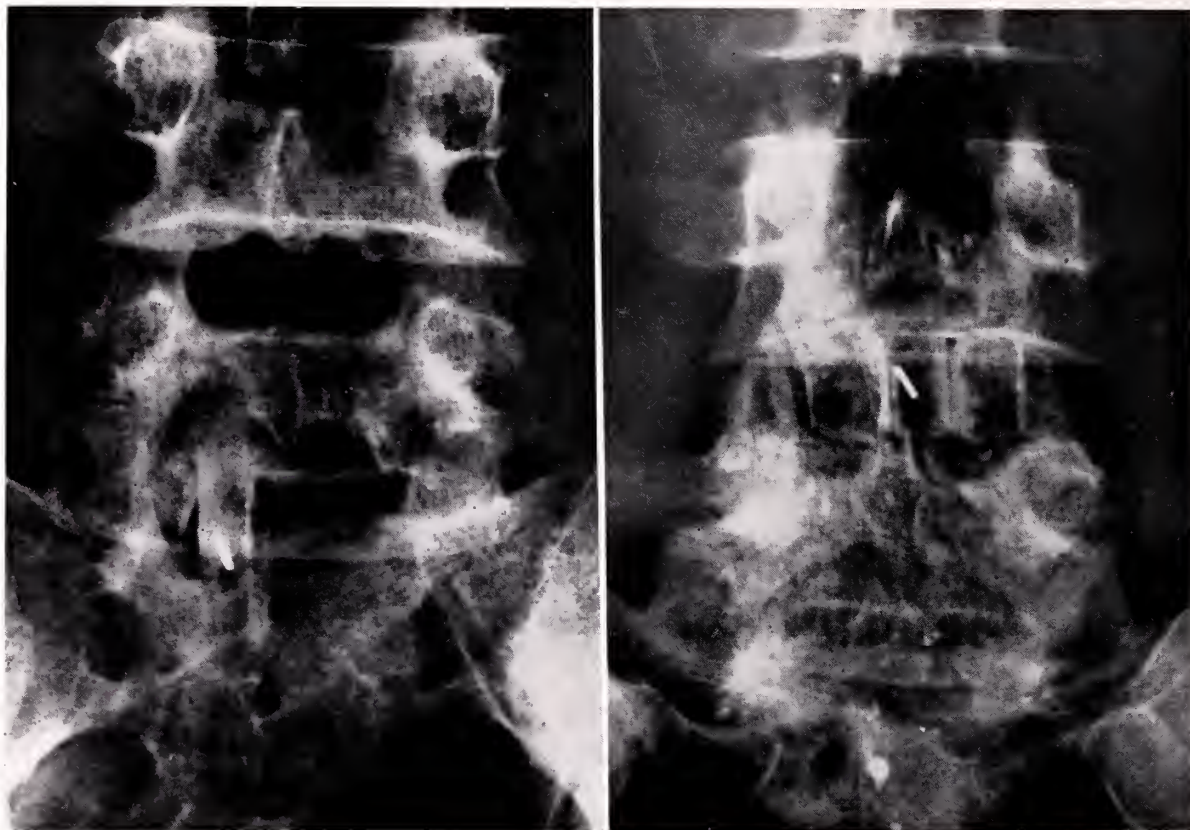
a. Antero-posterior x-ray of vertebral body fusion (1944). One bone wedge used to replace part of lumbo-sacral disc removed at site of herniation. b. Three bone "plugs" replacing intervertebral disc L4-5 (1949).
